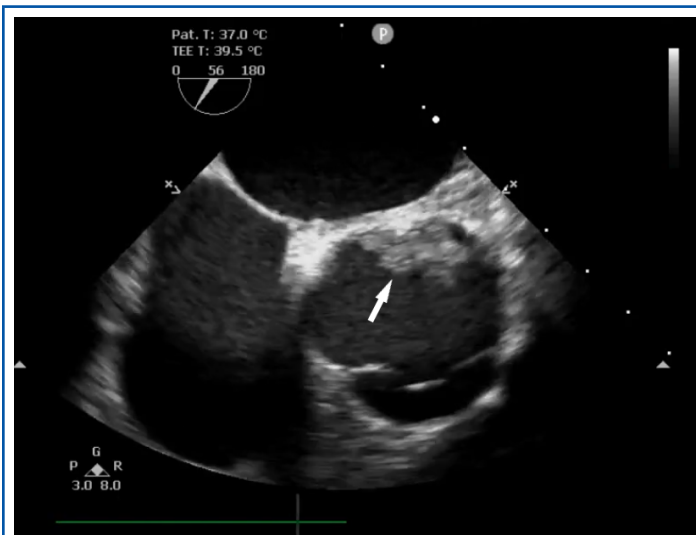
2D transesophageal echocardiography – mid-esophageal short axis view. The presence of a mobile mass (arrow), irregular, apparently with a pediculated insertion point near the commissure between the aortic noncoronary and left coronary cusps is confirmed.
